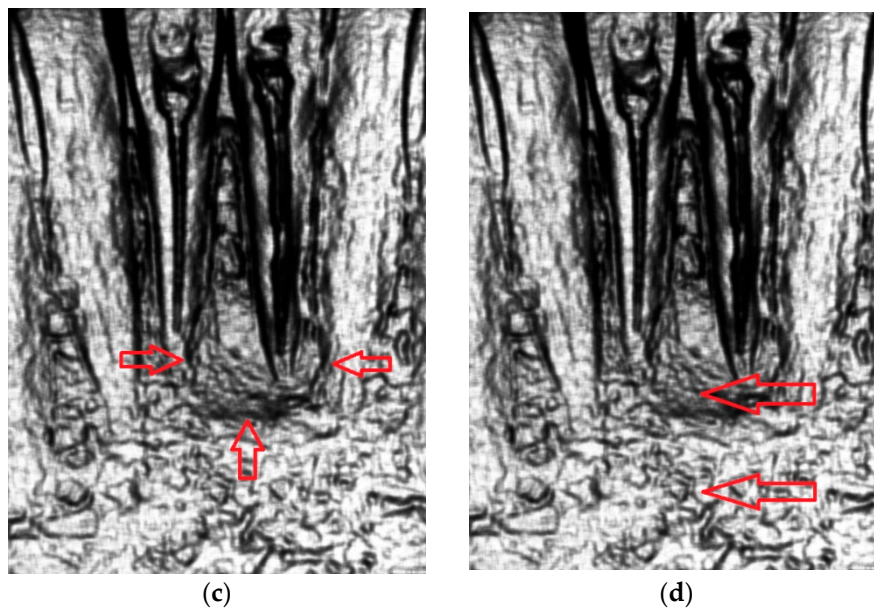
Example of assessment of a periapical lesion. (a) Entry digital intraoral radiographic image. (b) Differentiation of radiodensity in the lesion (different shapes are pointed out by the arrows). (c) Border definition (pointed out by small arrows). (d) Tissue contrast between lesion and the neighborhood (shown by the arrows).
